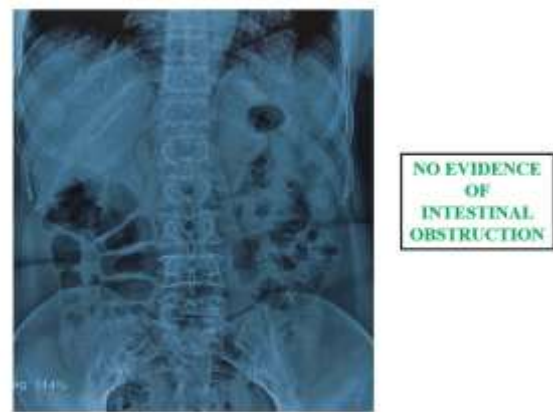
Xray Erect Abdomen showing both psoas shadows, and no signs of intestinal obstruction
